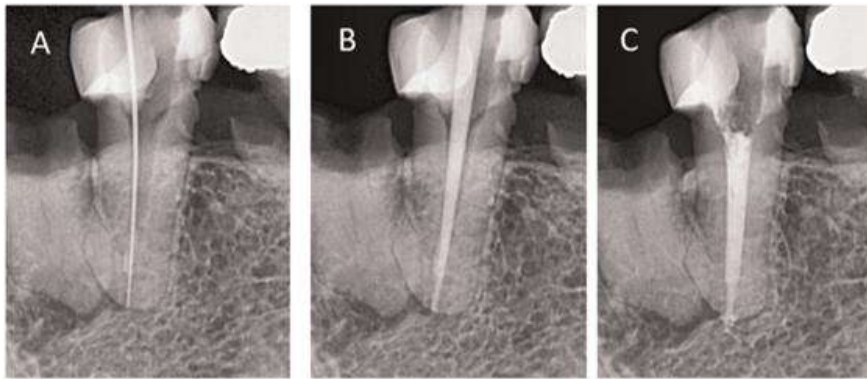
Periapical radiograph of A. Working length. B. Masterpoint. C. Obturation.
